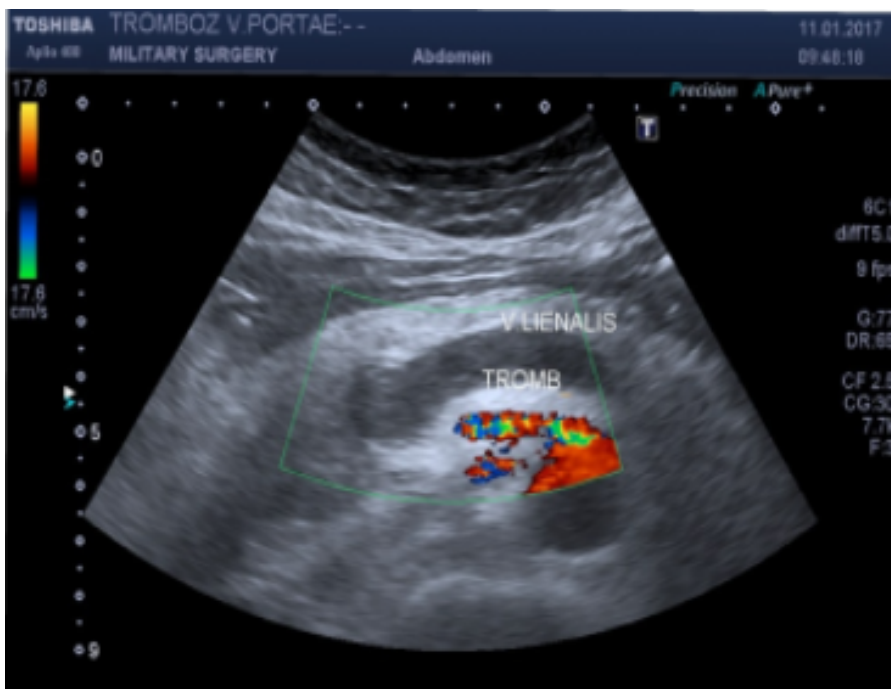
Ultrasound examination of a 72-year-old woman with toxic cirrhosis reveals a thrombus in the portal vein, which spreads to the branches (splenic and superior mesenteric veins), which caused mesenteric thrombosis and intestinal necrosis.
